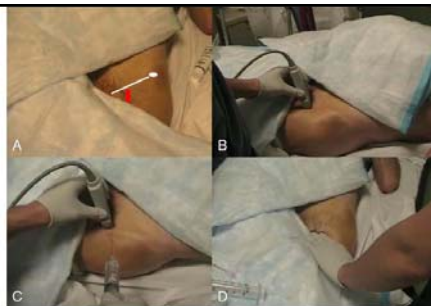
Ultrasound guided femoral nerve block. A, Supine patient demonstrating landmarks of the anterior superior iliac spine (white oval), inguinal ligament (white line). B, Orientation of US probe. C, Injection of anesthetic. D, Manual pressure distal to the injection.
